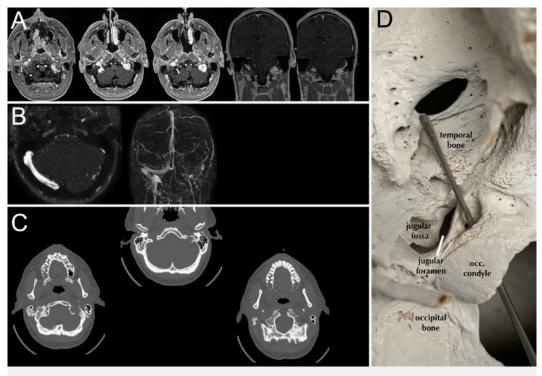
MRI (A) and MRA (B) show a lesion with uniform contrast enhancement in the left jugular foramen and complete blockage of the left transverse and sigmoid sinuses. CT scans (C) showing a cystic erosive lesion of the occipital bone, compromising the jugular foramen and posterior part of the condyle without involvement of the petrous bone. Inferior view (D) of the skull base showing the jugular fossa and jugular foramen. occ. = occipital.
